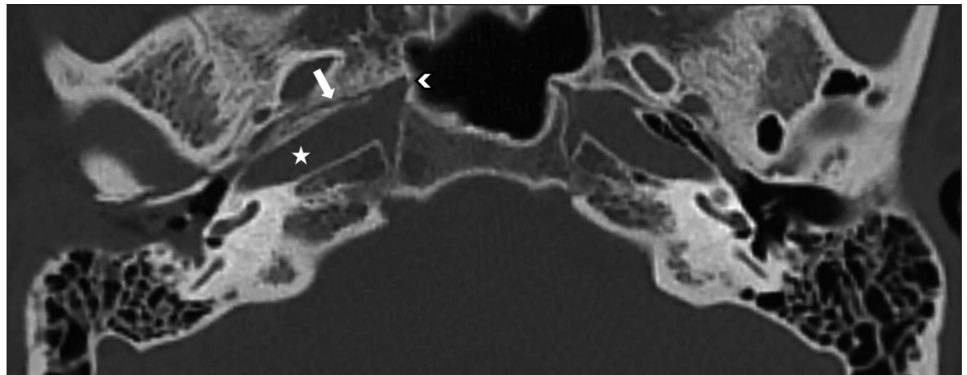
Axial CT image at the level of the basal turn of the cochlea. A fracture line runs longitudinally in the right skull base (white arrow). It extends into the petrous carotid canal (white star) and the posterolateral wall of the sphenoid sinus (white chevron).
